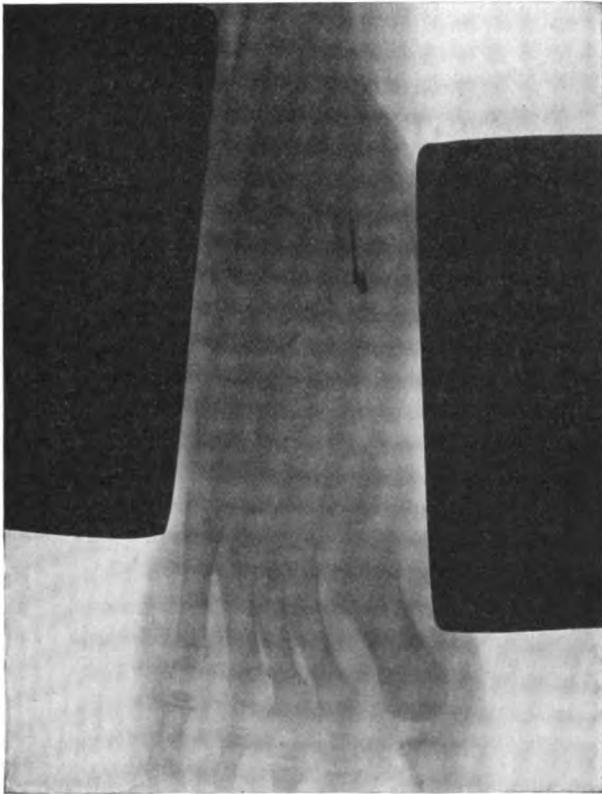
Localization of needle in heel. Anteroposterior radiograph. Bit of lead as external landmark.
